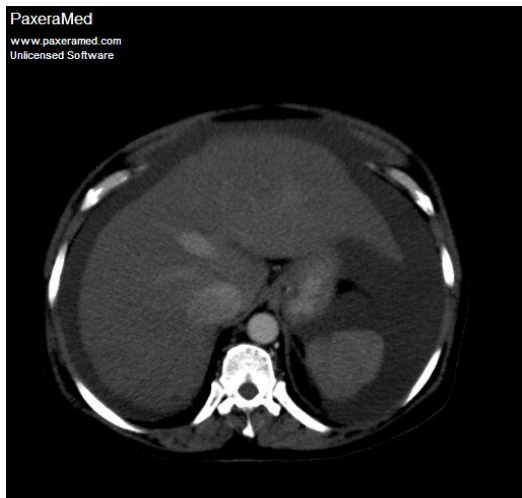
44 yrs F axial image CT shown massive asities with cirrhotic liver
